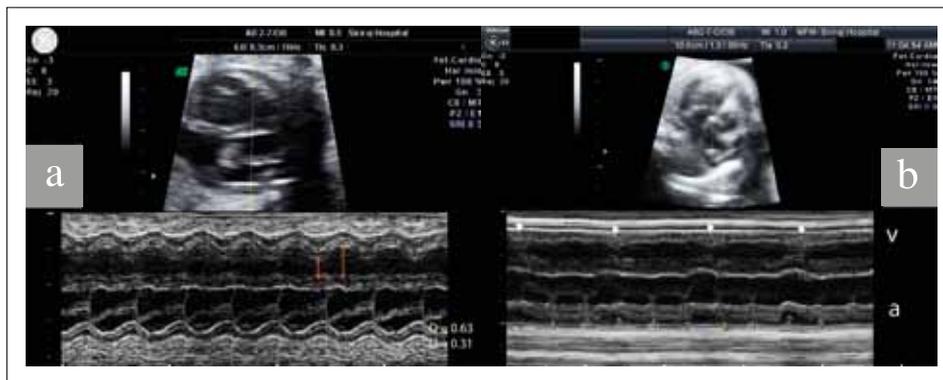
The use of M-mode ultrasound.
